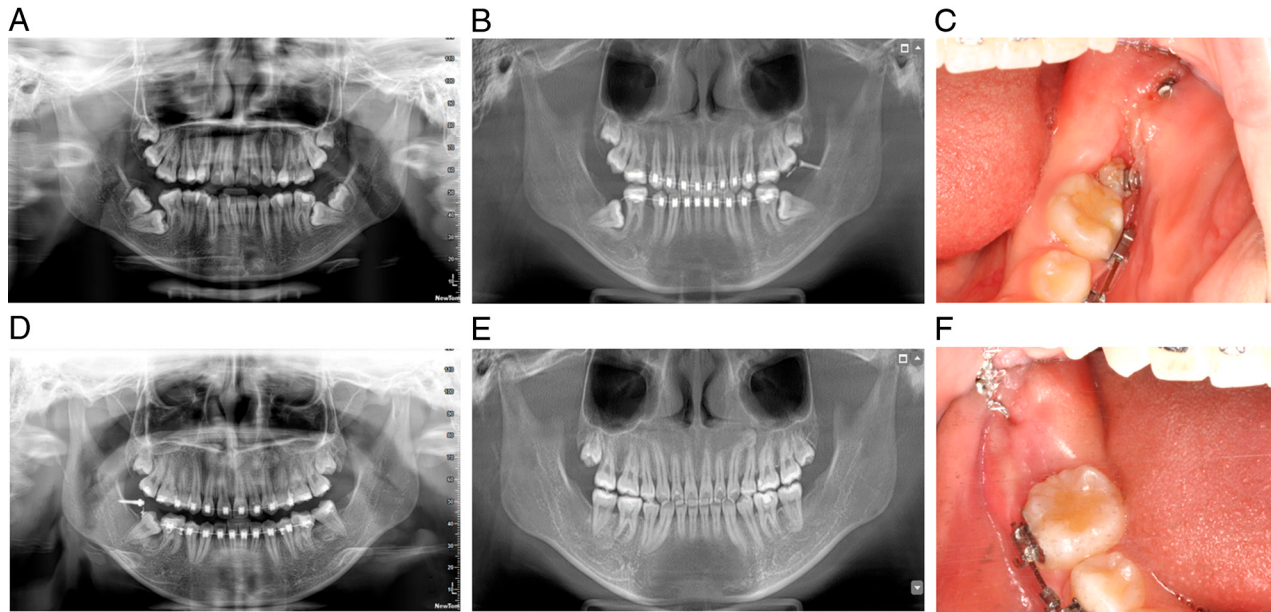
(A) Radiograph before treatment. (B) Radiograph after 3 months of orthodontic treatment. (C) Micro-implant anchorage implanted in the left mandibular ramus. (D) Radiograph after micro-implant anchorage implanted in the right mandibular ramus for 7 months. (E) Radiograph after treatment. (F) Micro-implant anchorage implanted in the right mandibular ramus.
